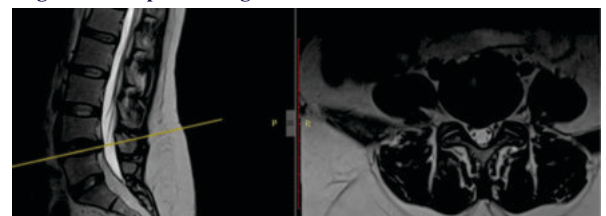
25yrs male: MRI sagittal and Axial T2W images showing disc protrusion at L4/L5 level.
